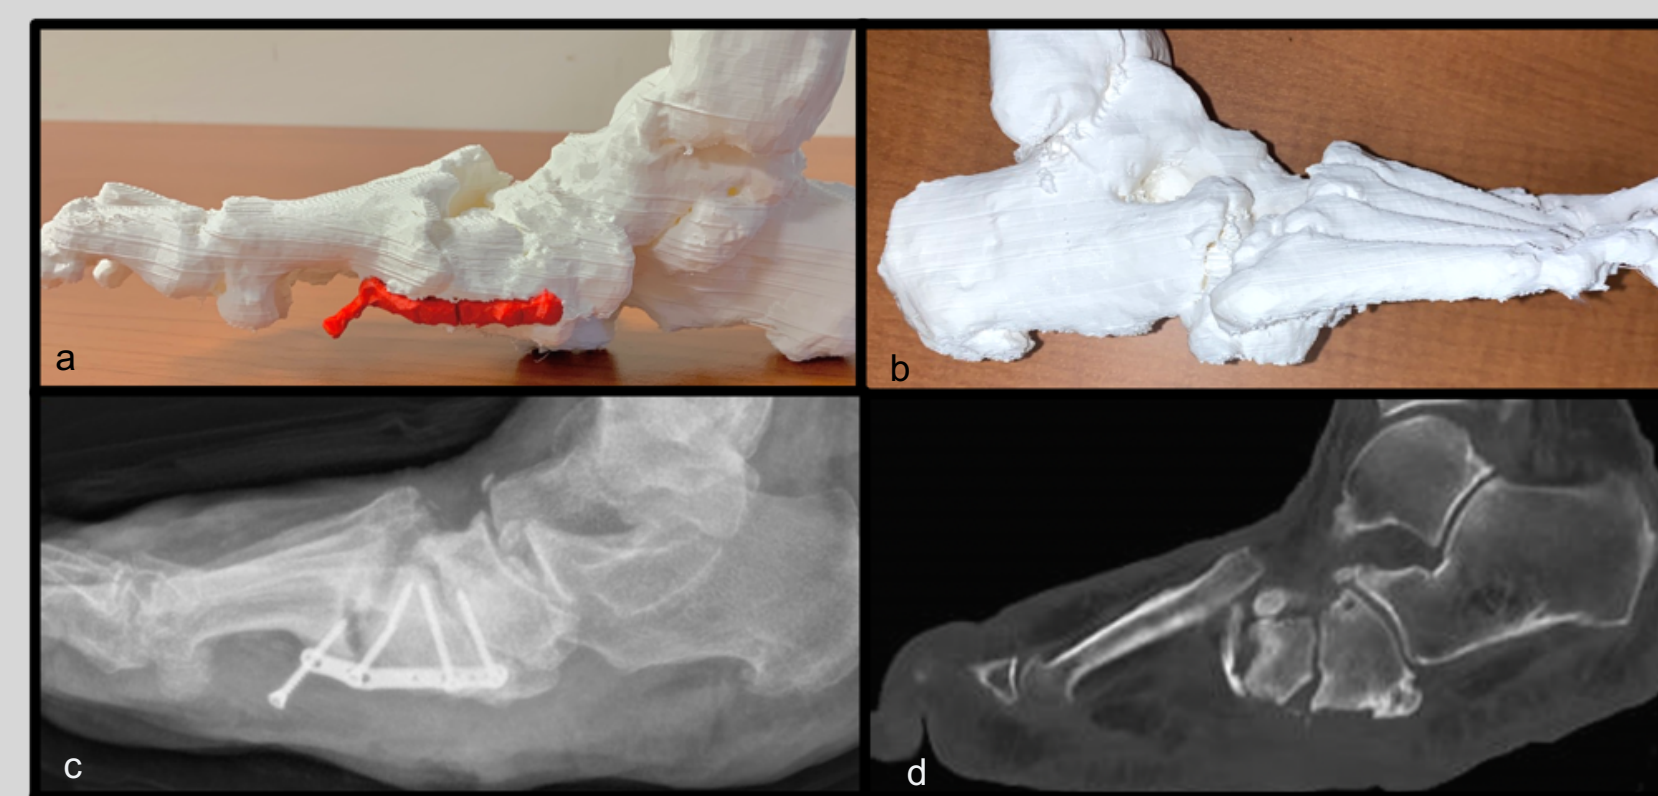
a: Medial view of 3-D printed model on weightbearing surface. b: lateral view of 3D model. c: lateral plain-film radiograph pre-operatively. d: sagittal CT scan showing plantar prominence, note the inability to view entire foot in one view.
